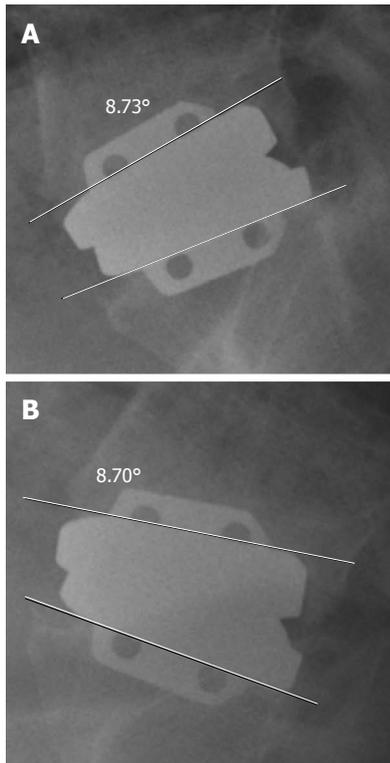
Two years after the operation, radiograph (Above: Extension; Below: Flexion) shows range of motion of the implant was almost 0°.
